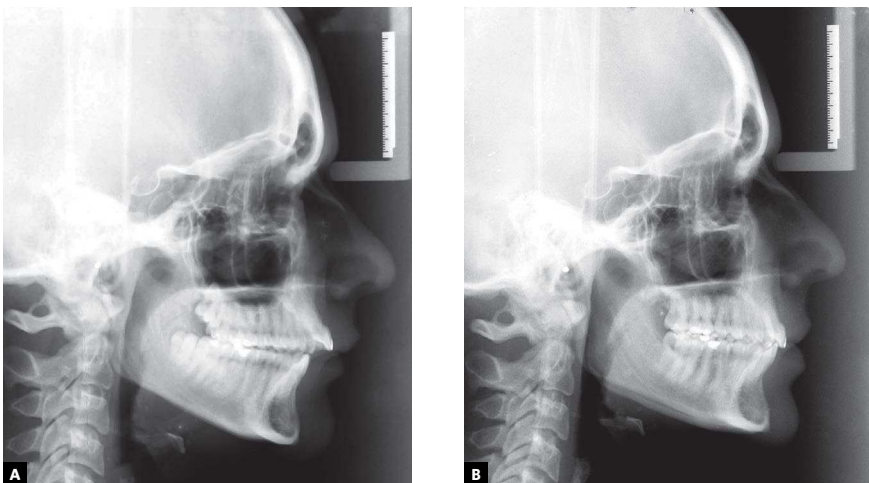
Baseline cephalogram of patient at 19.5 years of age shows a Class II division 1 malocclusion (A); treatment with rapid palatal expander and Herbst appliance for 2 years and 11 months, without surgery, completed with speech therapy, as shown in final radiograph (B).
